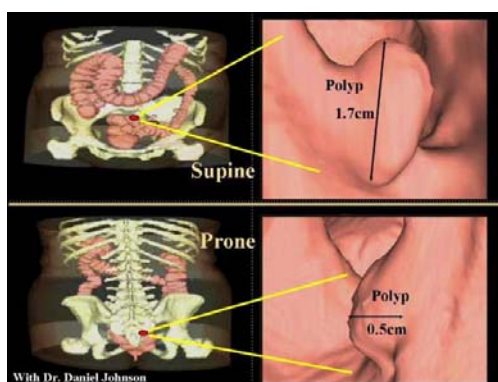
Virtual colonoscopy reveals polyps, their location, size, and composition from high resolution 3D CT scans.
